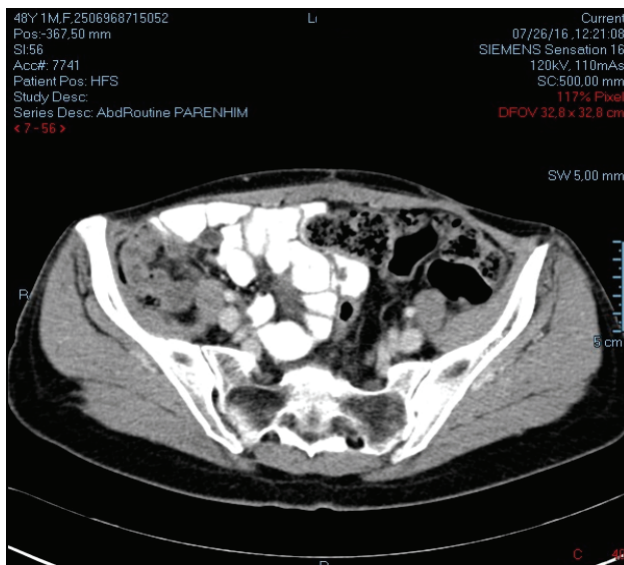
Pelvic computed tomography (CT) demonstrates normal bladder and intestines.
